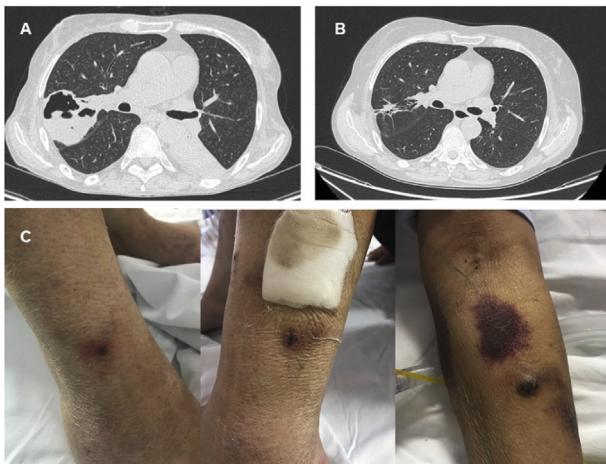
CT scan images. At +57 days (A) an excavated lesion was noted on CT scan image. Complete resolution was observed after nine months (B). Subcutaneous multiple nodular and erythematous lesions due to *Alternaria alternata* (C). Some of them had shallow ulceration and were spontaneously painful.
